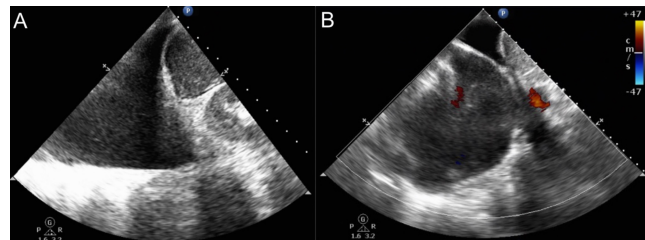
Bedside lung ultrasonography.
